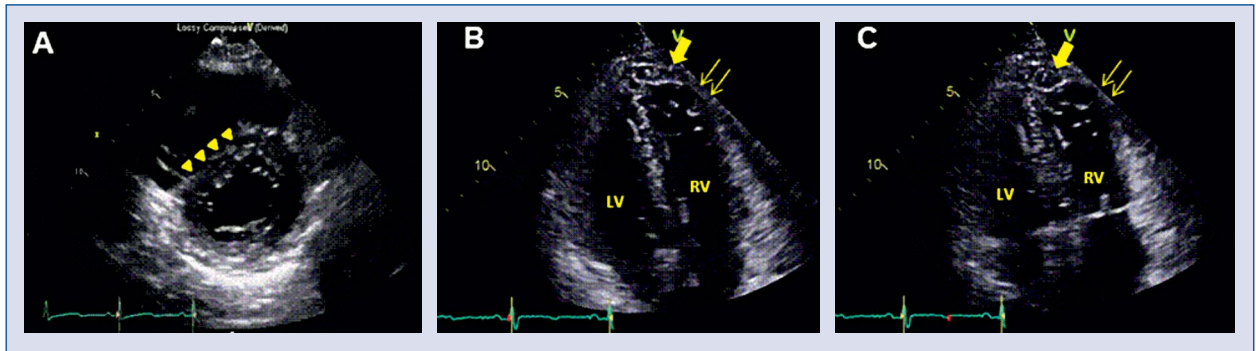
Transthoracic echocardiography demonstrating right ventricular (RV) dysfunction. D-shaped left ventricle (LV) (arrowheads) on parasternal short axis view represents RV pressure overload (A). RV enlargement and free wall hypokinesia with sparing of apical wall motion (McConnell's sign) on apical four-chamber view (B. At diastole; C. At systole).
